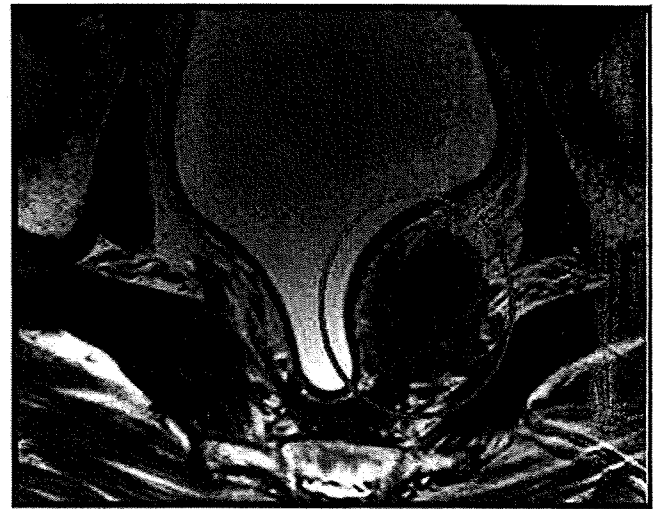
MR image of lateral recurrence, transverse MR image of local recurrence in the extramesorectal region (lateral subsite), highly suggestive of local relapse from nodal metastasis in the lateral lymph nodes.
